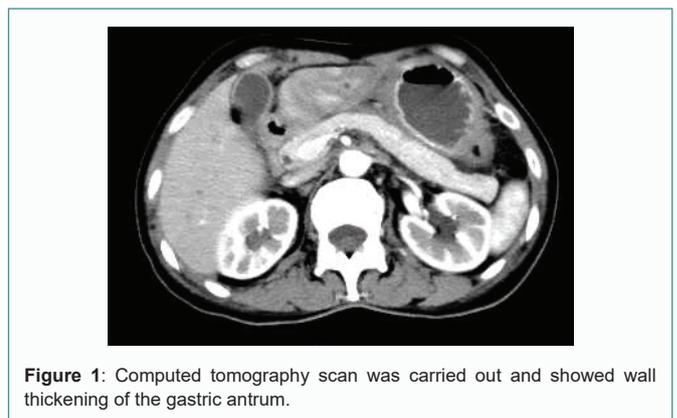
Computed tomography scan was carried out and showed wall thickening of the gastric antrum.
